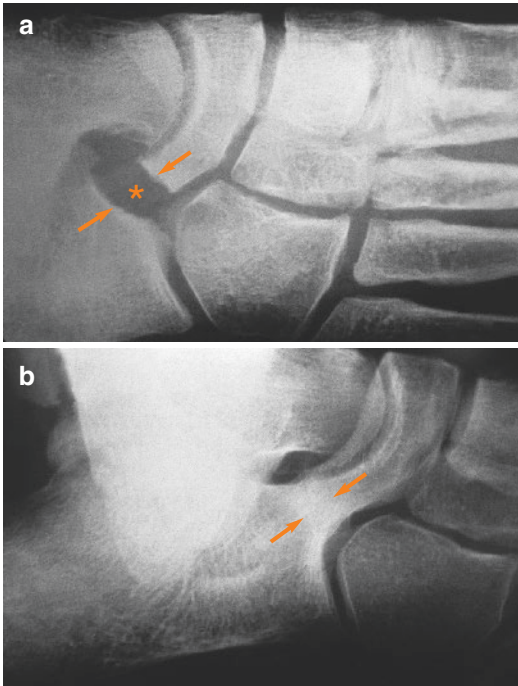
Oblique X-ray of the foot. (a) No connection between the calcaneus and navicular bones (*tarsal sinus). (b) Tarsal coalition (bony connection) between the calcaneus and navicular bones (between the *arrows*)
